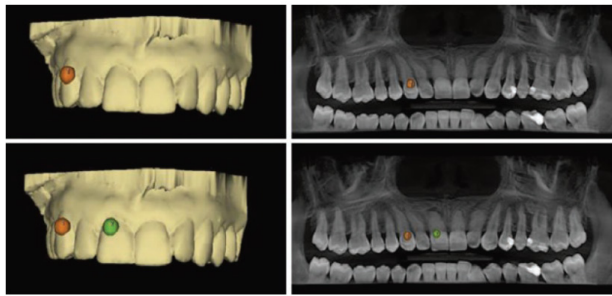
Superimposition of CBCT data and surface scan by marking three spots.
